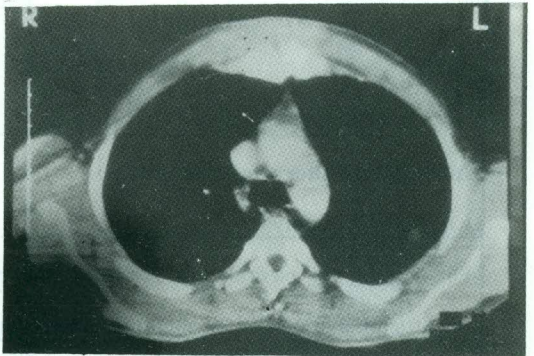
CT of chronic osteomyelitis of sternum.
